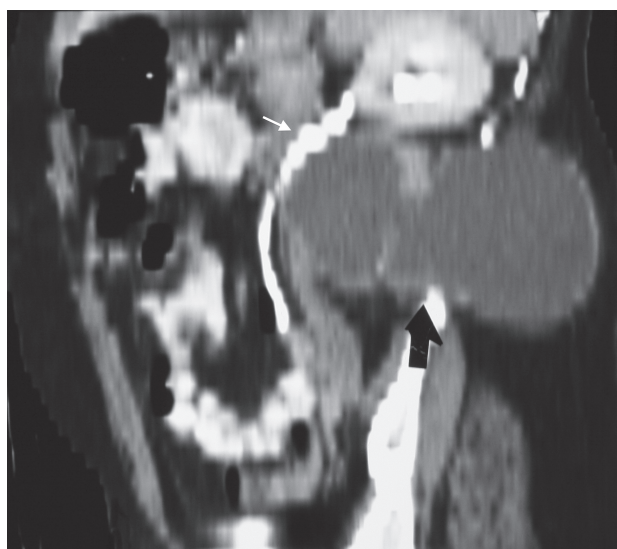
Post-contrast axial CT demonstrating a medially displaced right ureter (white arrow) splayed around non-enhancing cystic retroperitoneal masses (*); herniated cyst (black arrow).
